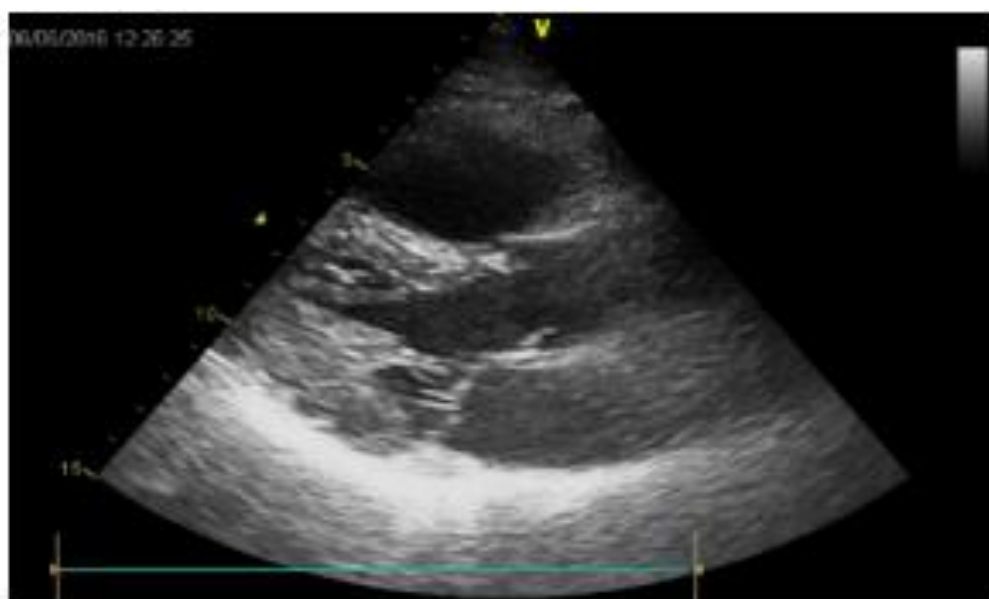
Transthoracic cardiac ultrasound - Dilated right ventricle
